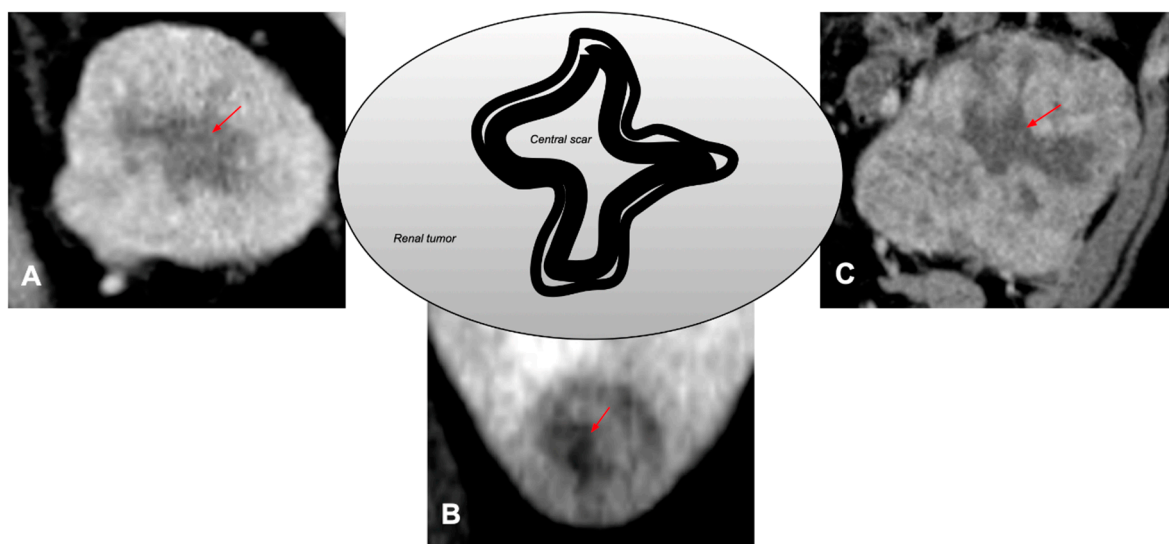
Examples of the “central scar” (red arrows) appearance on CT in an oncocytoma (A), Chromophobe renal cell carcinoma (B) and Clear Cell Renal Cell Carcinoma (C).
